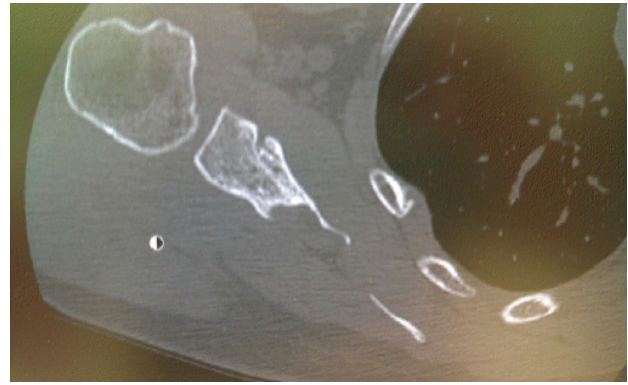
Axial computed tomography showing defect of scapular body.
